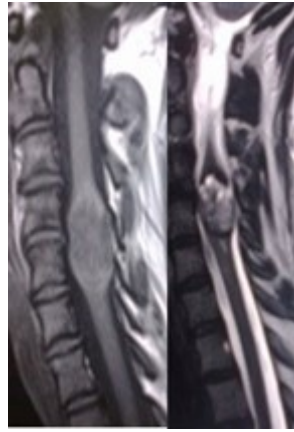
MRI of cervical spine (sagittal views, T1W and T2W images—right and left, respectively) showing intramedullary cavernoma. Source: Figure by authors.
